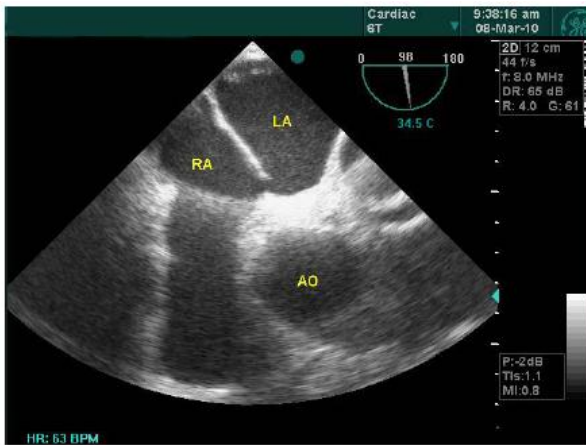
Transesophageal echocardiography (TEE) in four chamber view revealed a large patent foramen ovale. LA, left atrium; RA, right atrium; AO, aorta
